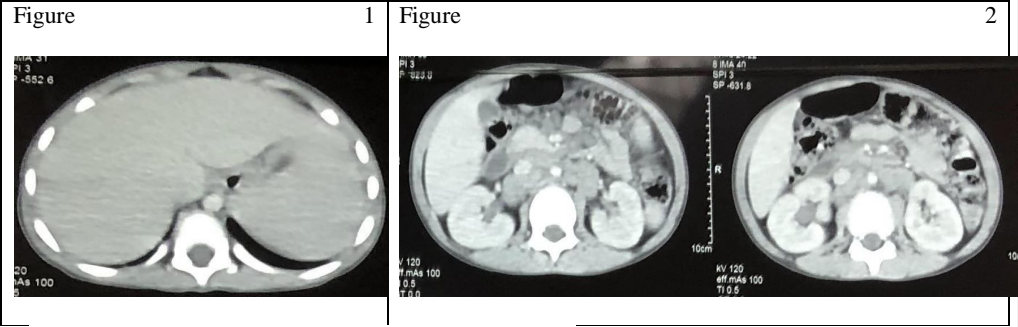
The cervico-thoraco-abdominal CT scan
